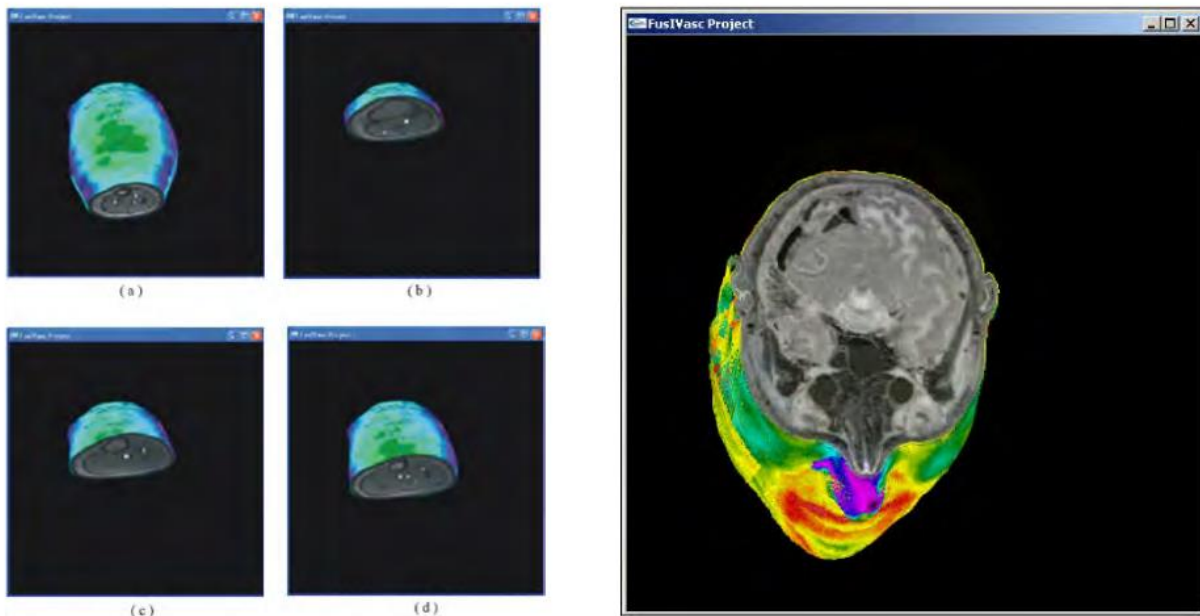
head visualization at dorsal root axial cut and visualization at four distinct cutting levels. In both cases, the MRI data is visible together with the surface temperature. The images were taken from [87].
